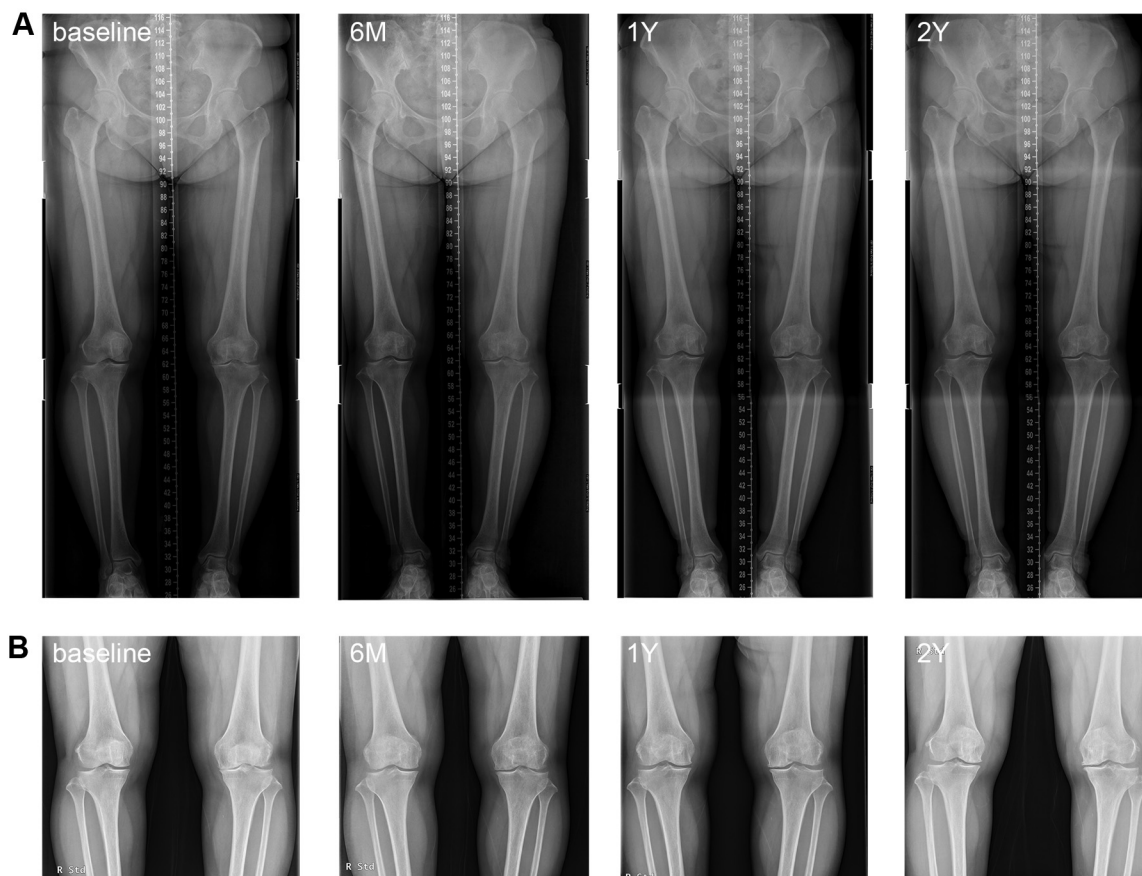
Changes in the appearance of the knee after an intra-articular injection of adipose tissue–derived (AD) mesenchymal stem cells (MSCs) (A) on standing teleradiography of the lower extremity and (B) on standing anteroposterior radiography of the knee. The Kellgren-Lawrence grade was determined as 3 at baseline and did not change over 2 years. The joint space width measured 2.6 mm at baseline and 3.5 mm, 1.8 mm, and 2.2 mm at 6 months, 1 year, and 2 years, respectively. The mechanical axis was 19.9% at baseline and 22.2%, 19.1%, and 20.1% at 6 months, 1 year, and 2 years, respectively. The anatomic axis was -1.7° at baseline and -2.1° , -0.5° , and -0.6° at 6 months, 1 year, and 2 years, respectively. All the measures were not significantly different between the time points.
